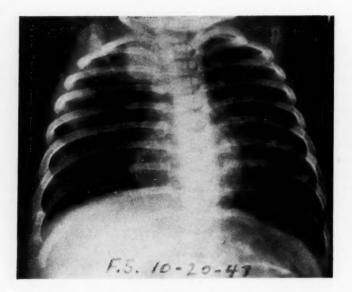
Case 2.—Roentgenogram showing a shadow in the right upper lobe area for which the patient was admitted. The diagnosis of fibrocystic disease of the pancreas was suspected when bronchoscopic findings were found to be incompatible with other clinical evidence.
